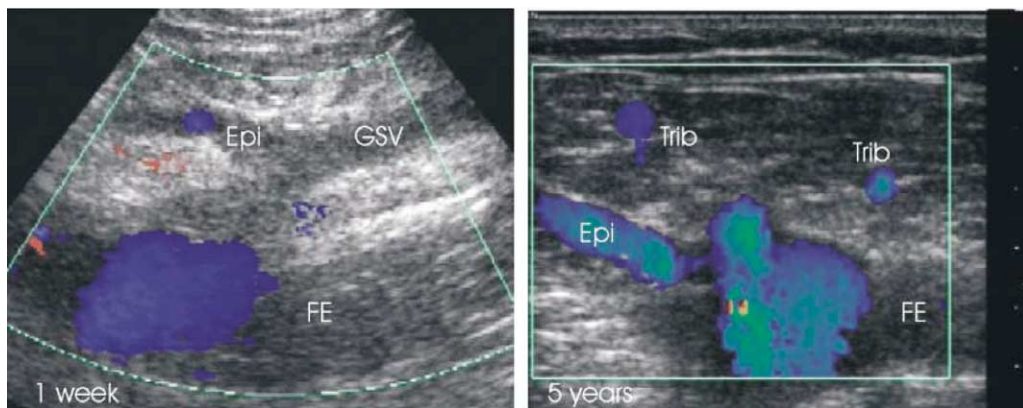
On the left, a duplex ultrasound image of the area near the saphenofemoral junction 1 week after radiofrequency obliteration of the great saphenous vein (GSV). The image on the right was recorded at the 5-year follow-up. Transverse views of patent tributaries (Trib) are seen. There are no longer any discernible landmarks for the GSV, Epi, Superficial epigastric vein; FE, femoral vein. (Images courtesy of Olivier Pichot, MD)
